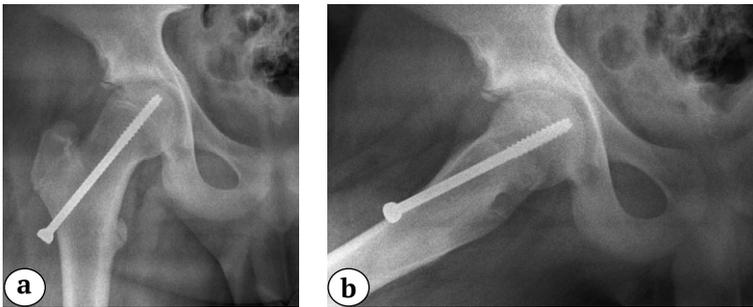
X-rays of the right hip in the anteroposterior projection (a) and in the Lauenstein projection (b) of patient 13 years 11 months old, immediately after surgery. Interpretation is in the text
